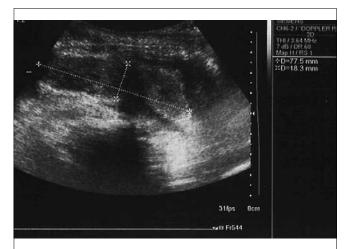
Ultrasound scan showing a thrombus in the right posterior cavernous body.
